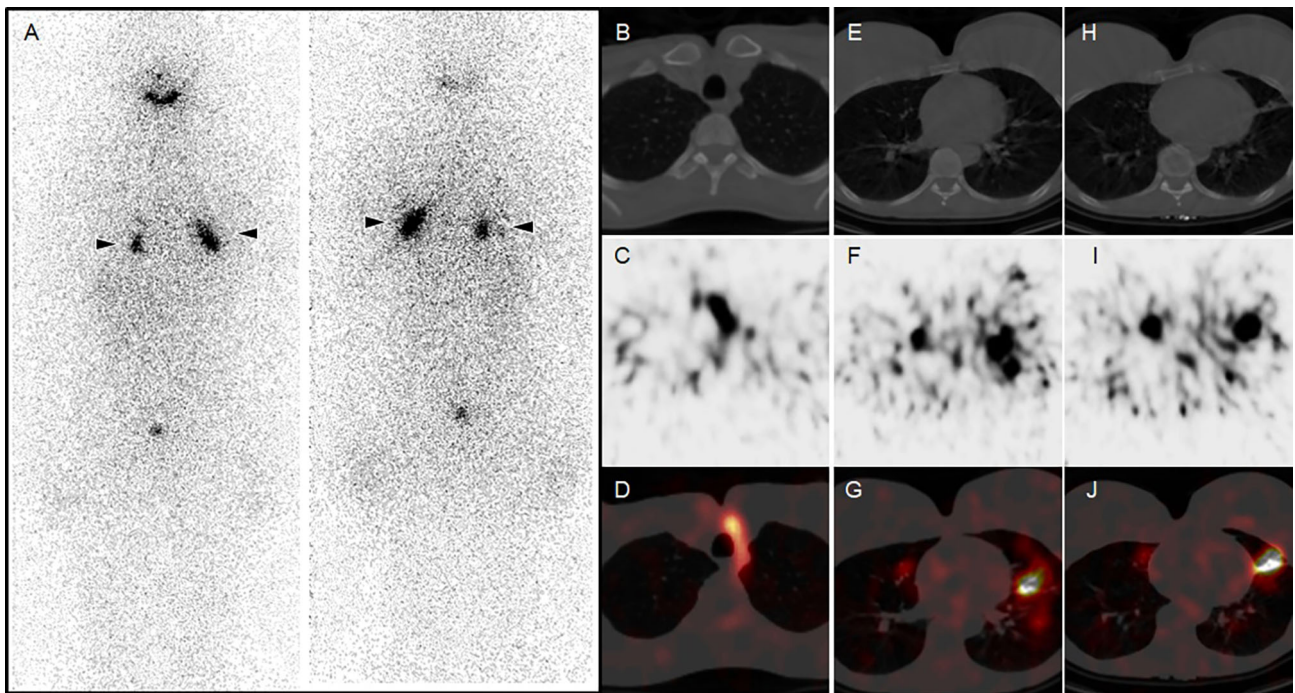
Imaging after repeat I-131 treatment. a RAI-WBS with accumulation in the lungs and the thyroid bed. b CT, c SPECT, and d transaxial fused SPECT/CT identified thyroid bed radiopharmaceutical uptake. e, h CT, f, i SPECT and g, j transaxial fused SPECT/CT identified bilateral pulmonary radiopharmaceutical uptake
